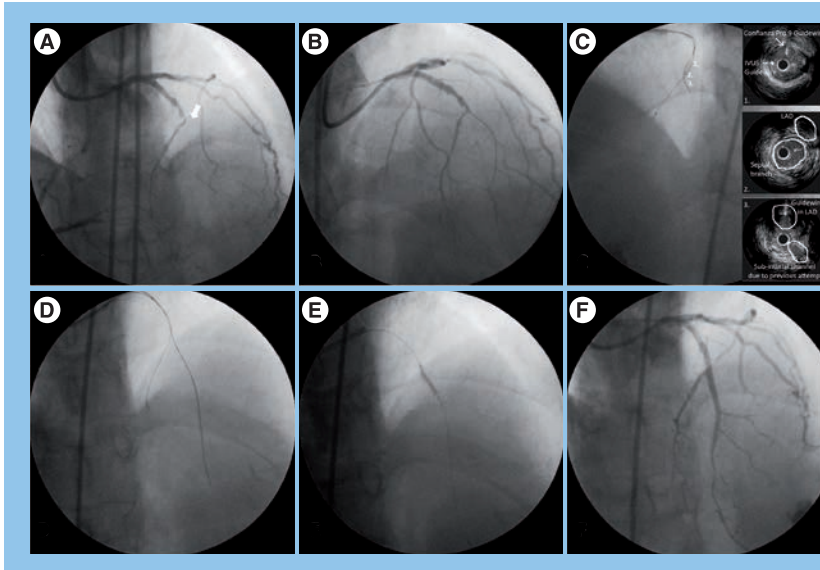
Intravascular ultrasound to detect the correct entry site for the guidewire tip. (A) Left anterior descending chronic total occlusion (CTO) with blunt stump (arrow) and side branch at the proximal cap. (B) Anterograde approach using a stiff guidewire (Confianza Pro 9) into a low profile over-the-wire balloon (Falcon 1.0 × 10 mm) was performed; however, the guidewire penetrated in a false lumen. (C) An intravascular ultrasound (IVUS) probe was advanced into the septal branch in order to orientate the anterograde guidewire through the CTO entry site; the IVUS frames show the correct entry site of CTO (middle panel), the position of IVUS-guided wire and the previous guidewire induced dissection (bottom panel). (D) The stiff anterograde guidewire reached the distal true lumen and dilatations with low profile over-the-wire balloon (Falcon 1.0 × 10 mm) was performed. (E) Multiple dilatations with bigger balloons were then started. (F) The final result after two drug-eluting stent implantations.
